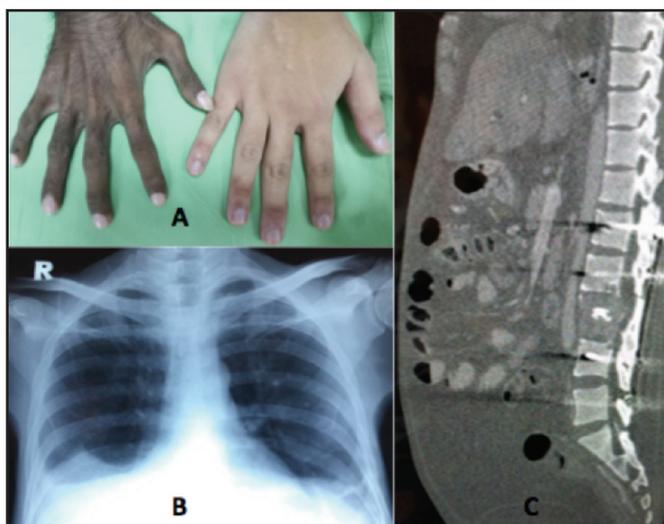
(A) Comparison between patient's right hand (left) with that of the physician's (right). (B) Chest radiograph showing bilateral pleural effusion. (C) CT spine showing osteosclerotic lesions over L3 vertebrae.
